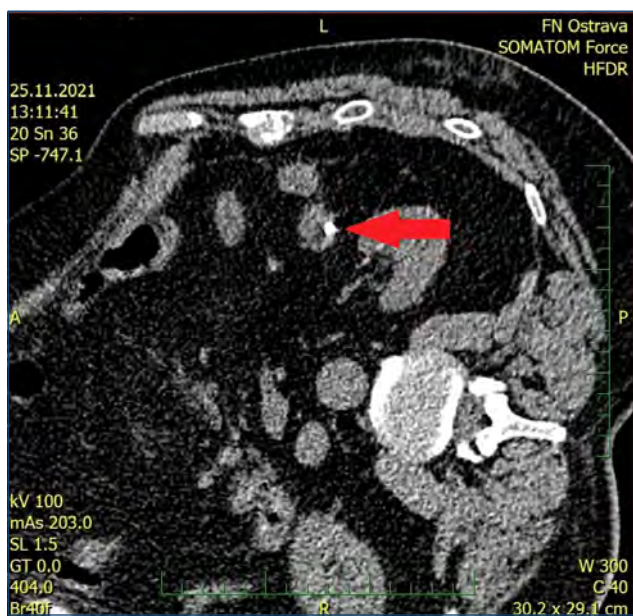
Settlement of the Magseed, utilizing a CT scan.
